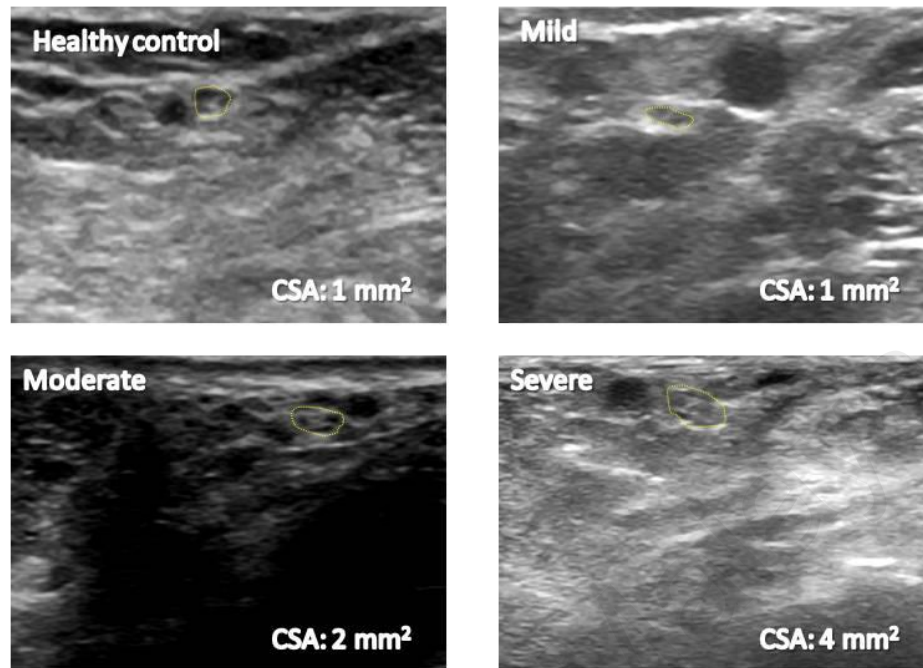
Sonogram of the sural nerve at 10 cm above the lateral malleolus (transverse view) of healthy controls and DM patients with different neuropathy severity showing a hypoechoic structure with hyperechoic dots within.
